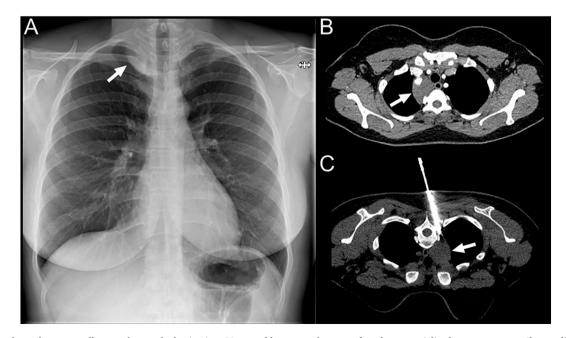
Incidentaloma that eventually turned out to be benign in a 32-year-old woman who was referred to a specialized sarcoma center. Chest radiography, which was performed because of fatigue, showed a right paratracheal lesion (A, arrow). The lesion is also shown on subsequent axial chest CT (B, arrow). CT-guided biopsy was performed (C) and pathological examination demonstrated a ganglioneuroma.
